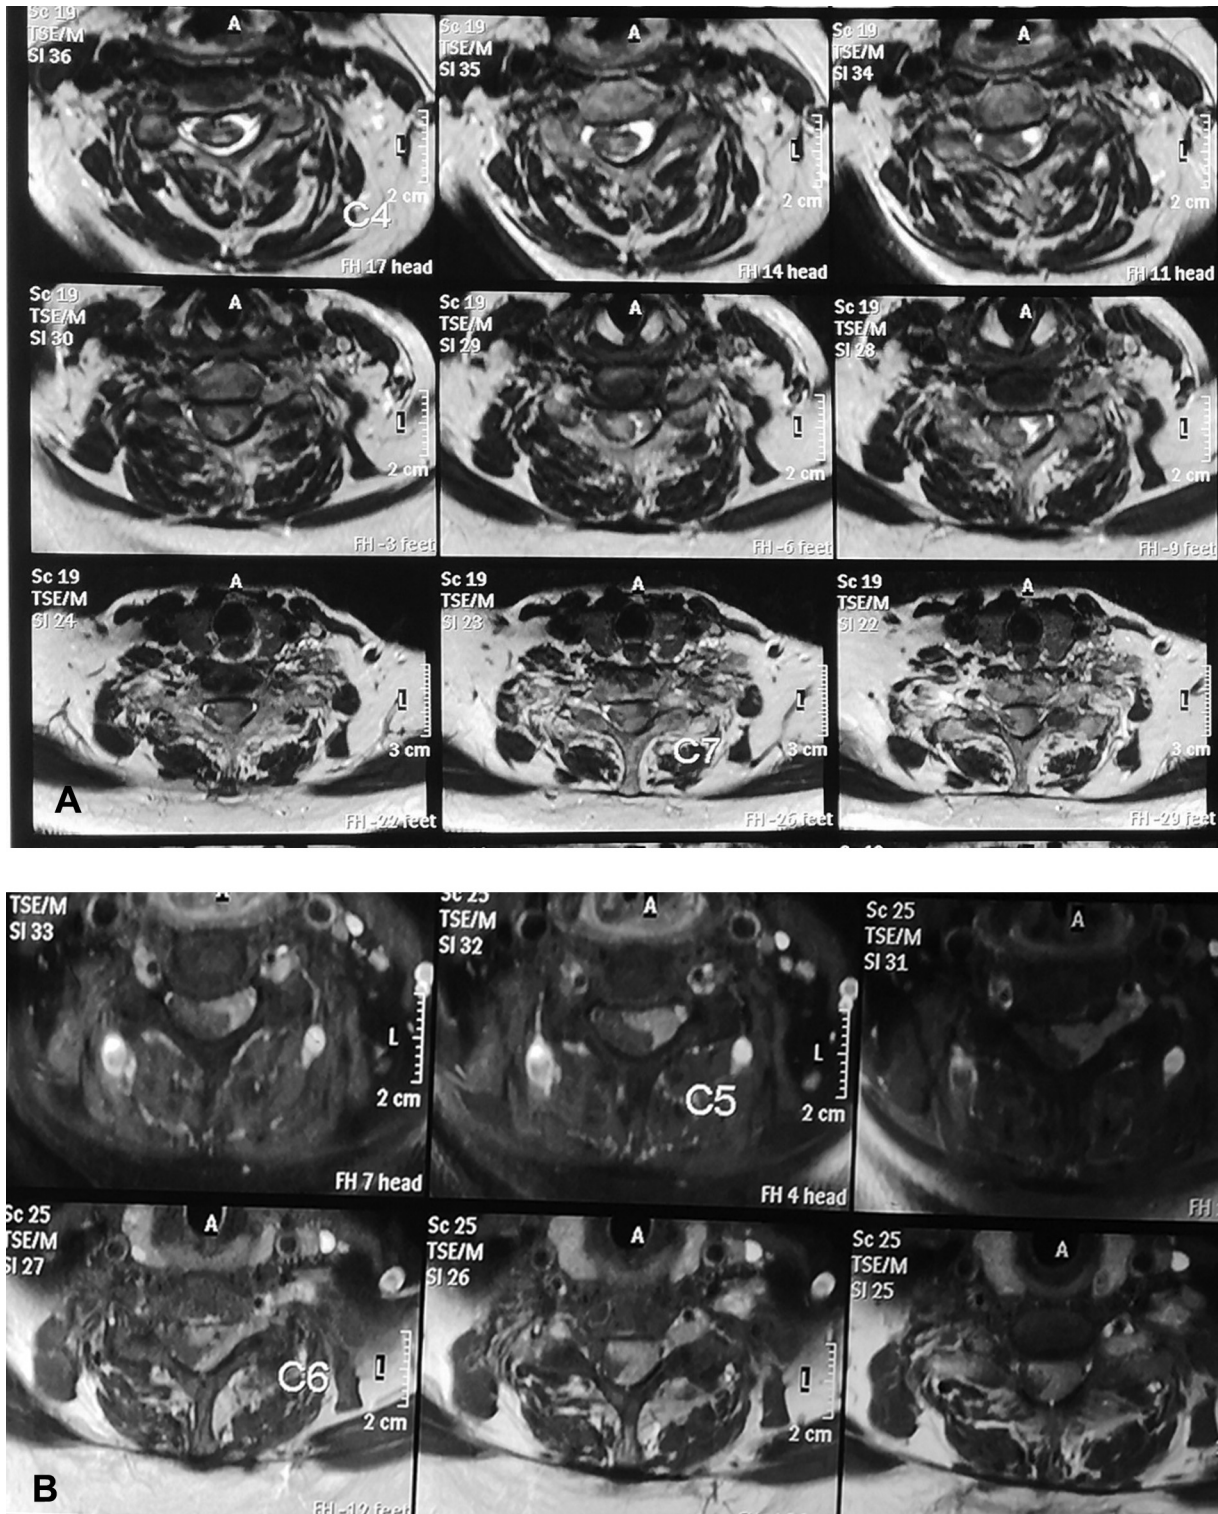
(A, B) MRI with gadolinium contrast showing enhancing lesion from C5 to T1.
